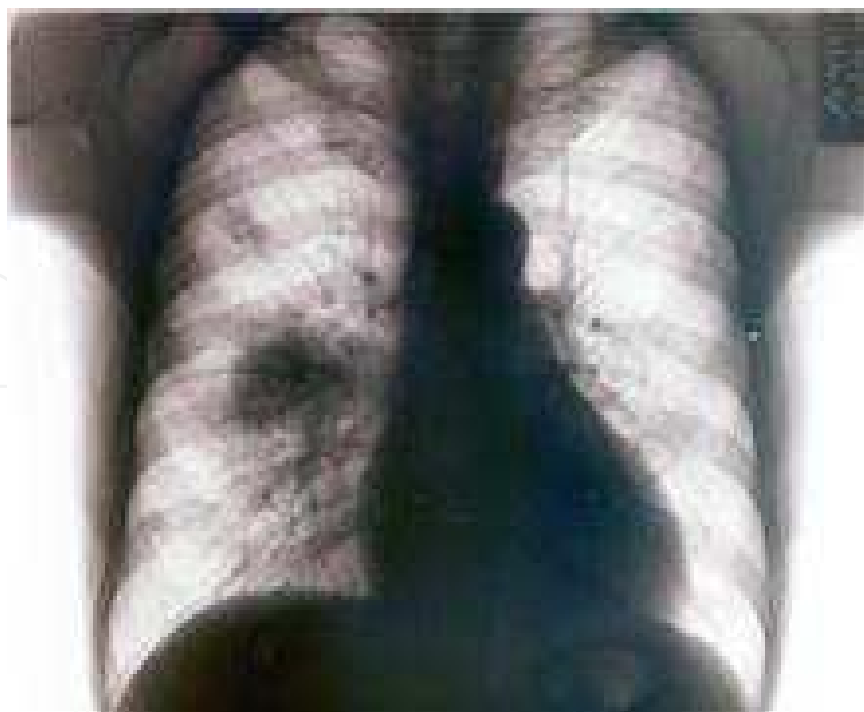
Radiographic changes associated with Nocardia infection.
